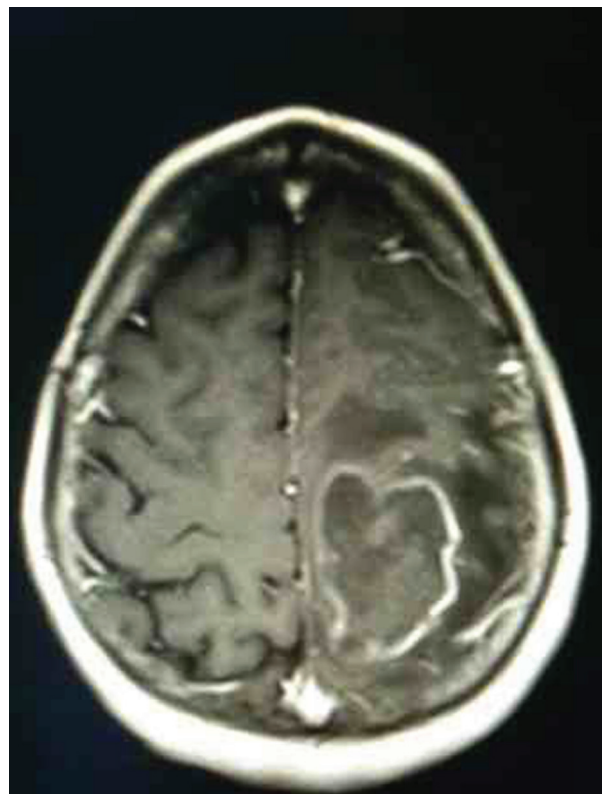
Postcontrast T1-weighted MRI brain.
